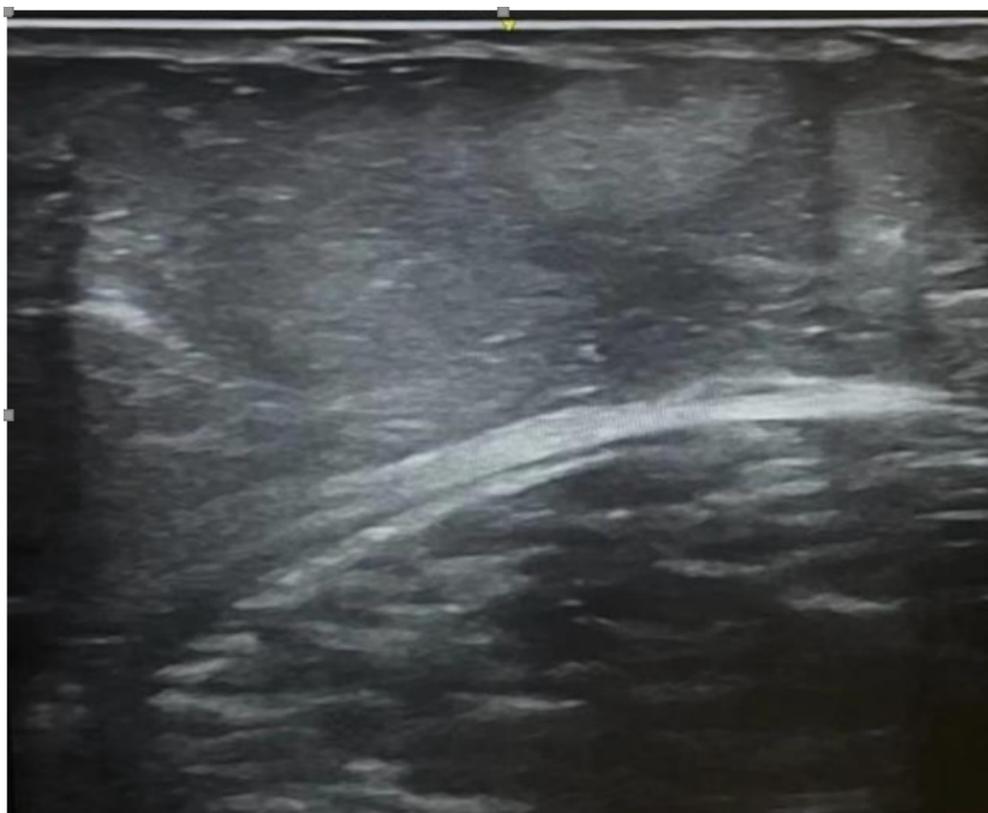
Ultrasonographic demonstration of the LDHC 3 ultrasound pattern: bulging hypodermis, disrupted septa, hyperechoic nodules, and irregular dermis-hypodermis interface.
